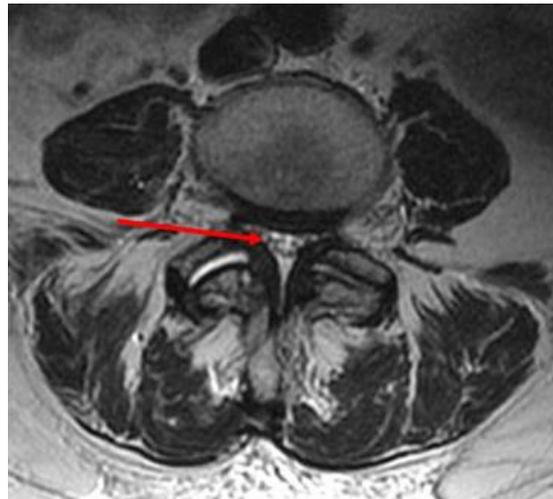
Axial MRI of lumbar spine demonstrating a disc protrusion causing a central spinal stenosis. Note obliteration of the (white) CSF signal (cauda equina compression).
